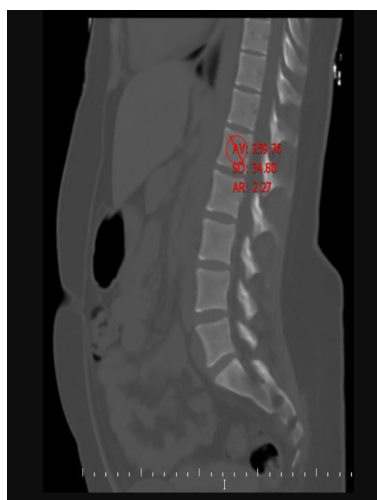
Midsagittal abdominal computed tomography image. Measurement of L1 vertebra bone mineral density with circle ROI is seen
